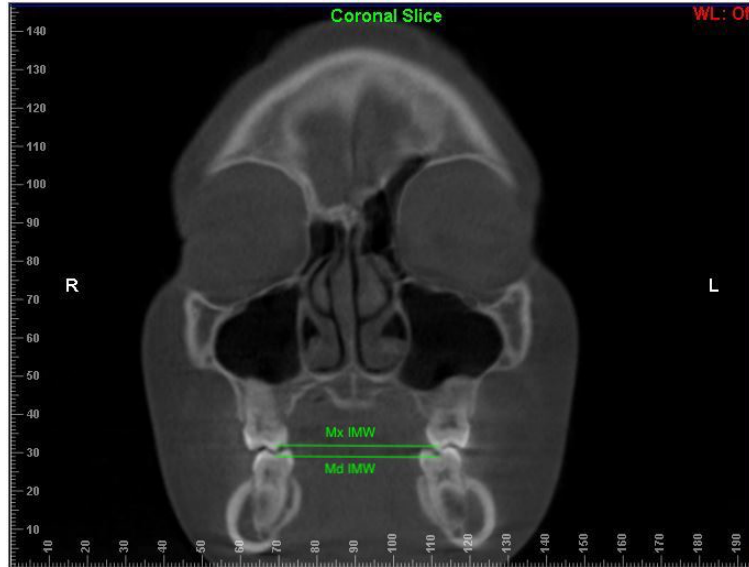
Coronal Slice of CBCT. Transverse measurements of maxillary inter molar width (Mx IMW) and mandibular inter molar width (Md IMW)
